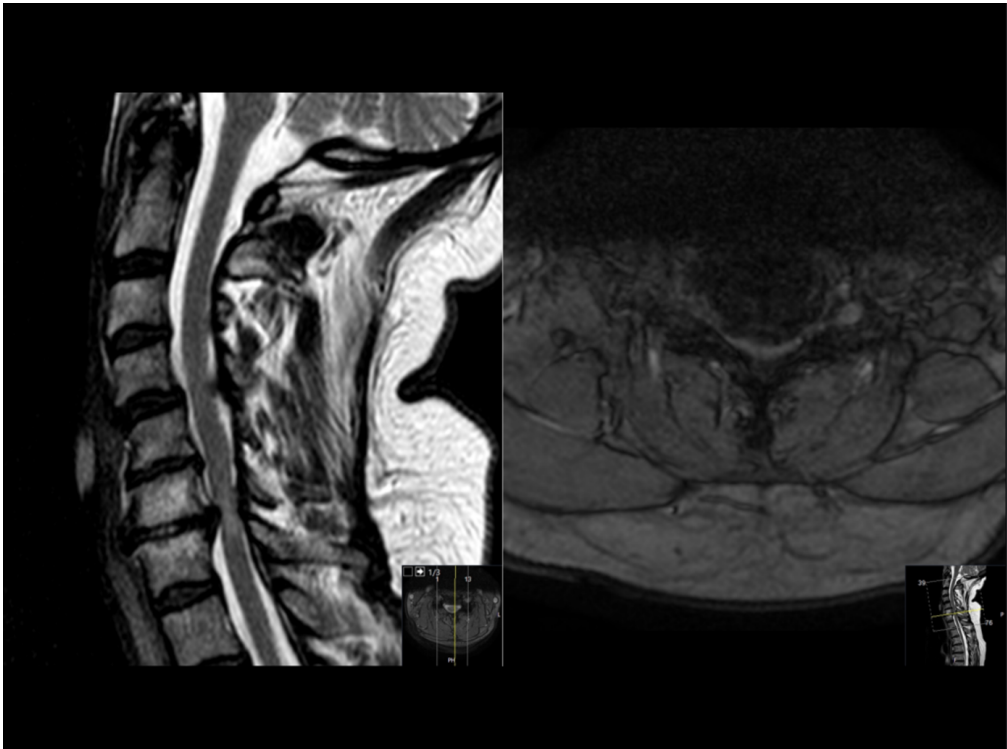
T2-weighted sagittal and axial MR images of a patient with severe degenerative cervical myelopathy due to disc herniation, ligament hypertrophy, and osteophyte formation at the C6/C7 level. On the sagittal images, one can see intramedullary signal changes. (Images provided by Prof. Sasha Gulati).
